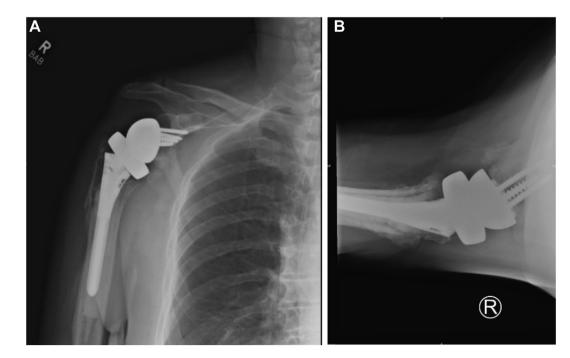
Postoperative x-rays at the 6-month follow-up. (A) An AP view of the right shoulder. (B) An axillary view of the right shoulder. AP, anterior posterior.
